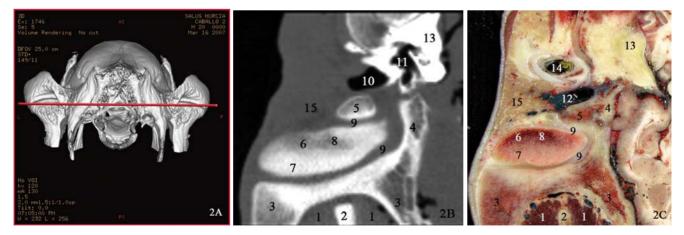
(A) Volume rendered 3D-reformatted image of the dorsal view of the right TMJ showing a dorsal-sectional plane of reference for Figures 2B and 2C; (B) Bone window dorsal CT image (window width = 2354; window level= 154) and (C) dorsal anatomical section (dorsal aspect) of the right TMJ. The progression of CT and anatomical images was from dorsal to ventral aspect. The lateral aspect is on the left side and the caudal aspect at the top of the image. 1 = temporal muscle; 2 = coronoid process; 3 = zygomatic process of the temporal bone; 4 = squamous part of the temporal bone; 5 = retroarticular process; 6 = mandibular condyle; 7 = articular cartilage; 8 = subchondral bone; 9 = articular disc; 10 = guttural pouch; 11 = tympanic part of the temporal bone (middle ear); 12 = caudal deep temporal vein; 13 = petrous part of the temporal bone; 14 = external auditory meatus; 15 = parotid salivary gland.
